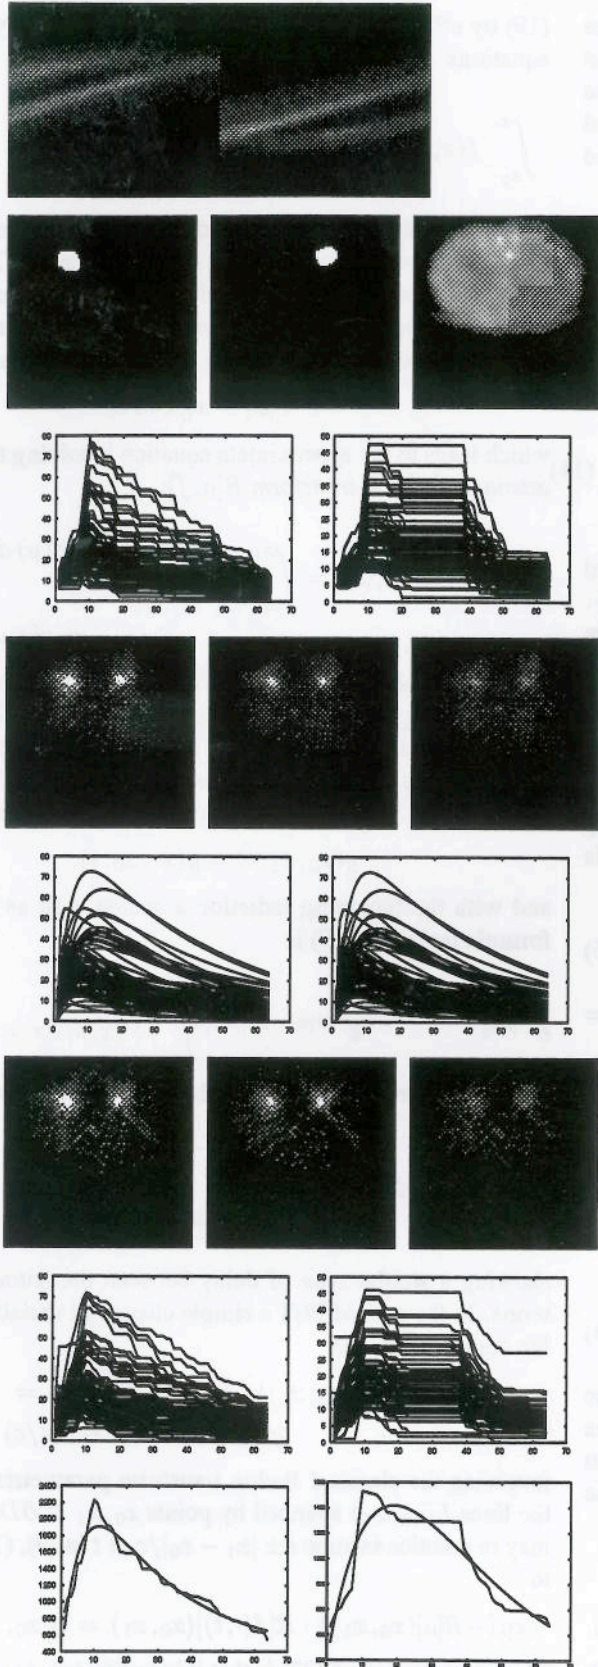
Results of a clinical dynamic SPECT experiment with the dynamic tracer TC-99mMAG3.
